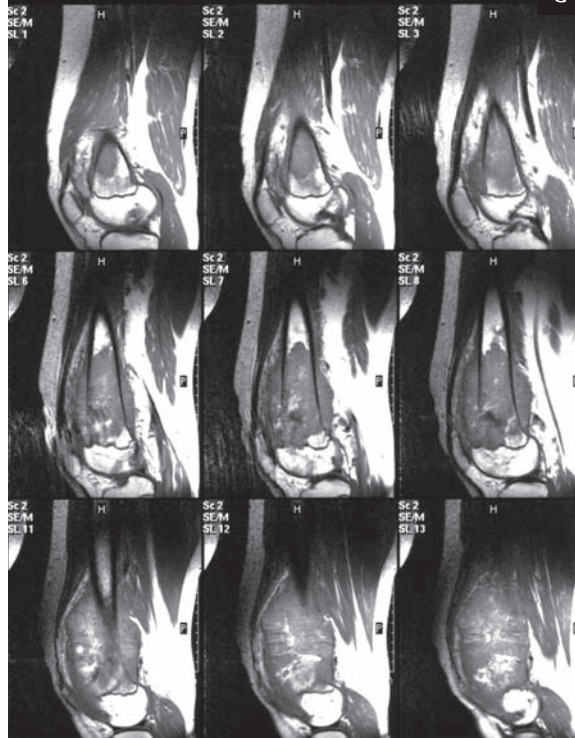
Osteogenic sarcoma of the femur. A. Plain film. Lytic and sclerotic changes (new bone formation), Codman's triangle, spicules, an extracortical tumor. B. US. An inhomogeneous extracortical tumor, pathological vessels, Codman's triangle. C. MRI. Bone destruction, calcifications, a big extracortical tumor. Medullary cavity infiltration does not exceed the boundaries of the bone tumor.
